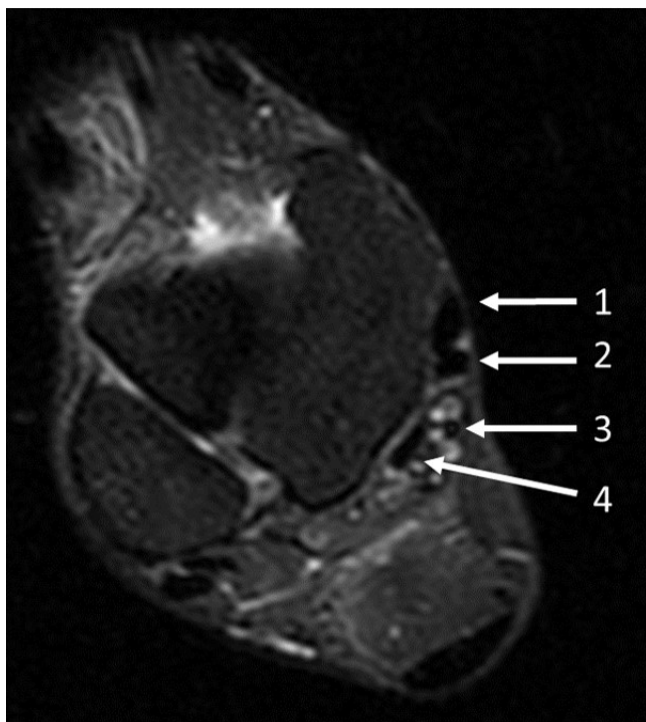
Axial magnetic resonance imaging showing the flexor digitorum accessorius longus; 1: Tibialis posterior tendon, 2: Flexor digitorum longus tendon, 3: Flexor digitorum accessorius longus tendon, and 4: Flexor hallucis longus tendon.
